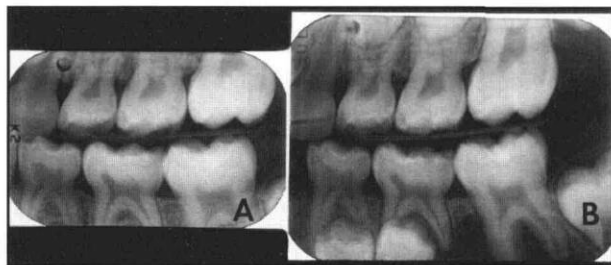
Bite-wing radiographs showing A) no apparent lesion one-year prior to the recall appointment and B) radiolucency apical to mandibular left first permanent and second primary molars and displaced second premolar.
